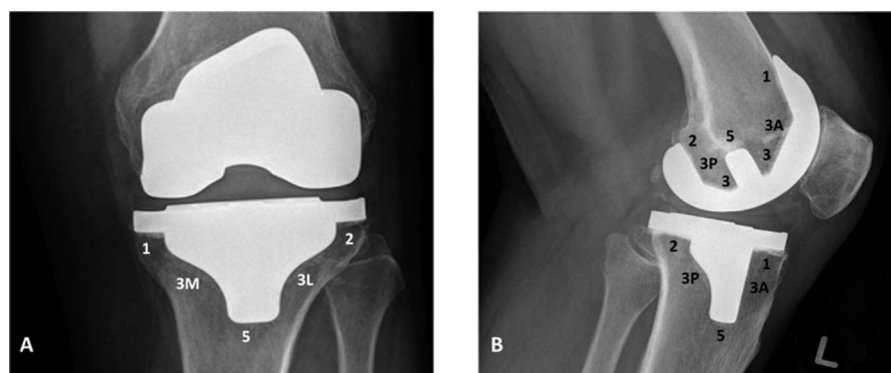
These (A) AP and (B) lateral radiographs show radiographic zones around tibial and femoral components (zones translated from Meneghini et al. [22]).
